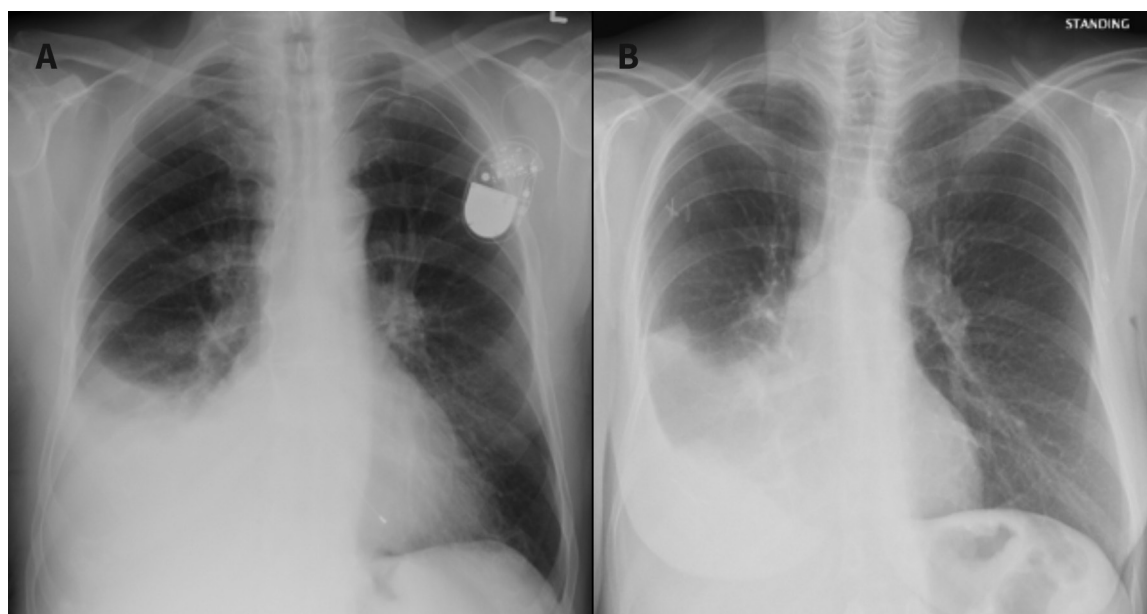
The effect of endobronchial obstruction in patients with pleural effusion on chest radiography. (A) A right pleural effusion without endobronchial obstruction. The trachea is midline. However, the trachea may be shifted to the contralateral side in a large effusion. (B) A right pleural effusion with obstruction of the right mainstem and intermediate bronchi by tumour. The trachea and mediastinum are shifted toward the effusion owing to atelectasis caused by the obstruction.
